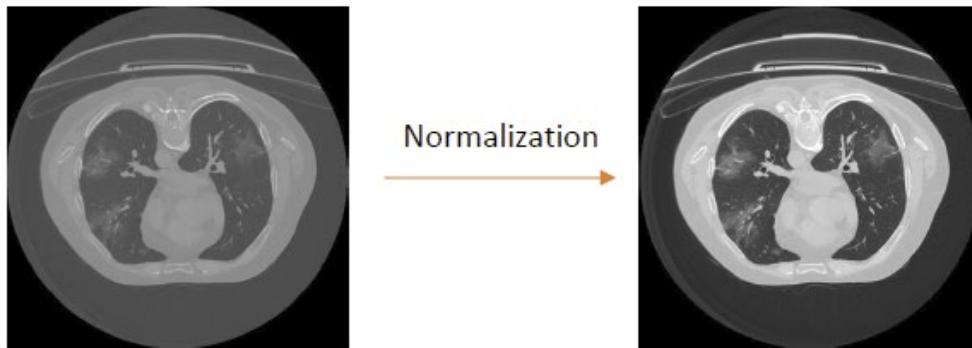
Normalization of CT Image
